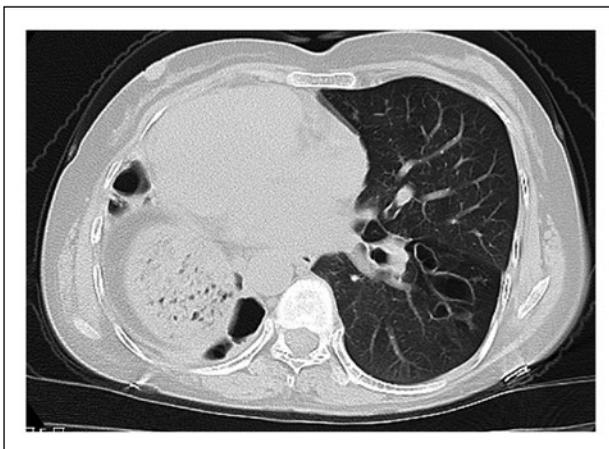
Chest CT - bronchiectasis in the lower left lung.
